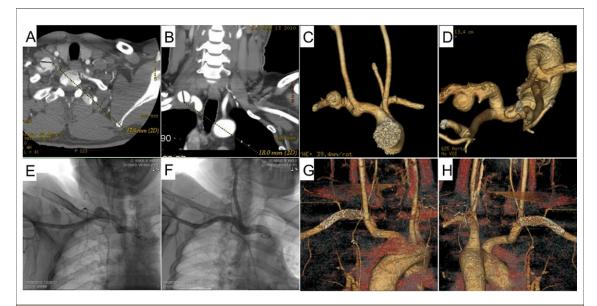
CT and Angiographic Images of Pseudoaneurysm
